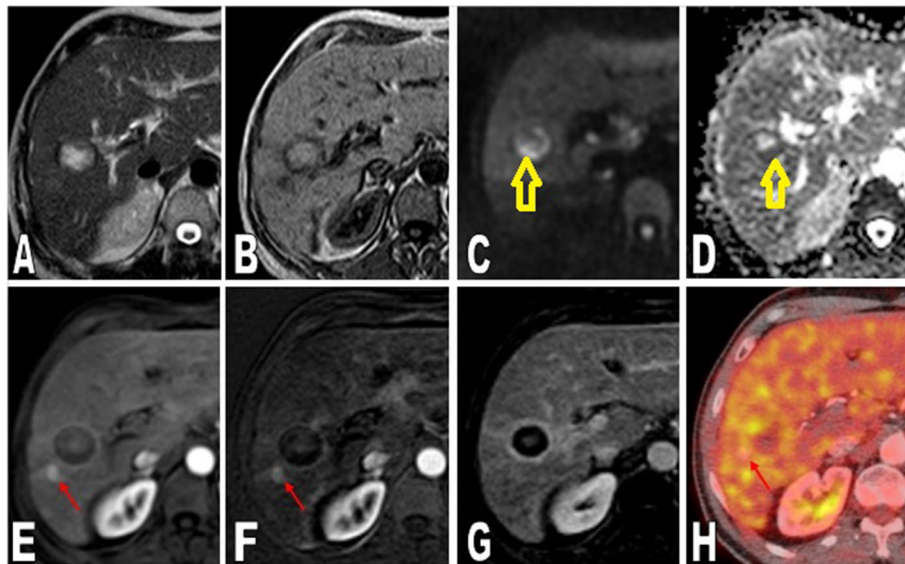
A 56-year-old male patient who underwent MWA for a right hepatic lobe HCC and imaged 3 months after the procedure. a Axial T2 WIs and b Axial T1 WIs showing the ablation zone within the right hepatic lobe elicits high T1 and T2 signal. c Diffusion-weighted images, d ADC map showed thick marginal area of restricted diffusion at the posterior margins of the ablation zone “yellow arrows” ($\text{ADC } 1.1 \times 10^{-3} \text{ mm}^2/\text{s}$). e Axial T1 3D THRIVE during the arterial phase. f The arterial subtraction and g the delayed phase showing no evidence of APHE or washout corresponding to the area of diffusion restriction “false negative for diffusion”. However, a small enhancing nodule is noted posterior to the ablation zone. h PET CT fused image showed FDG uptake at the enhancing nodule “arrows” confirming the tumoral activity (LR-TR viable) while the area of diffusion restriction showed no FDG uptake confirming the dynamic MRI findings (LR-TR nonviable)
